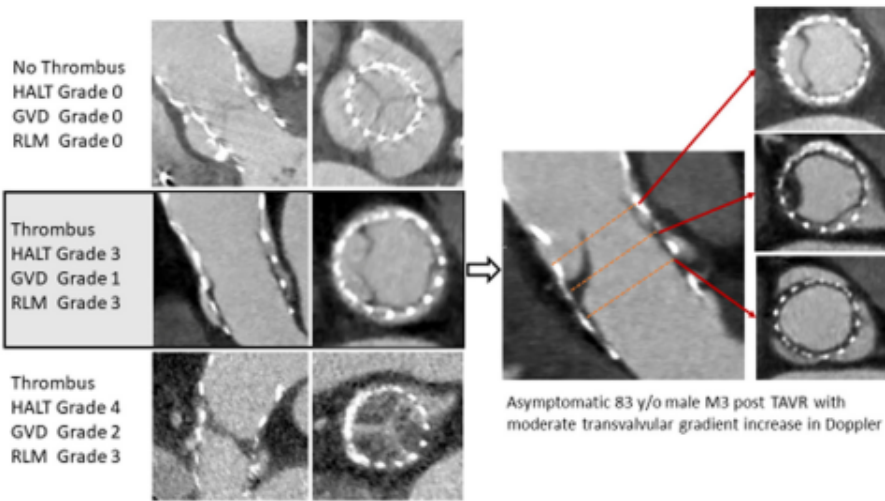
Grades of Valvular Thrombosis on 4-Dimensional Computed Tomography
